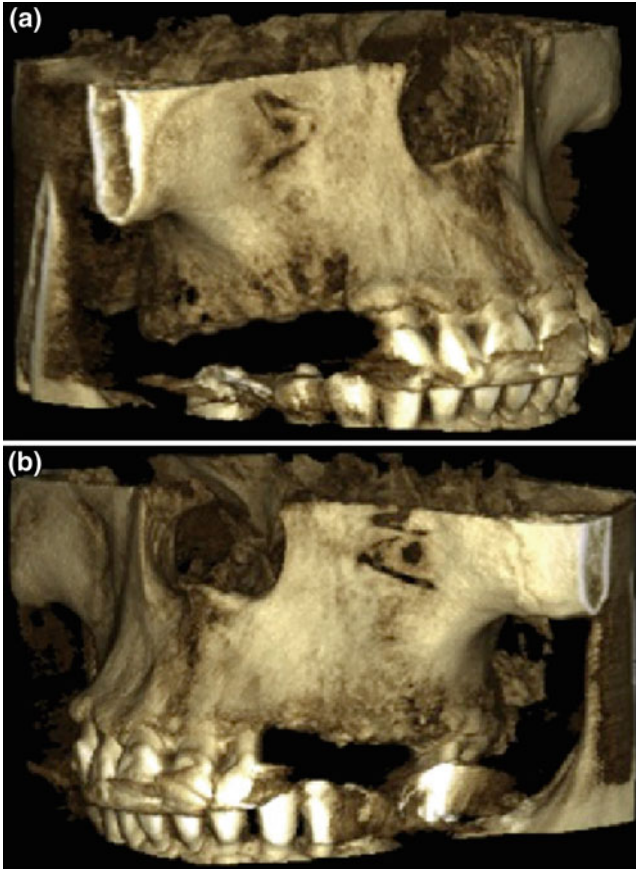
Preoperative CBCT: 3D reconstruction of right (a) and left (b) edentulous maxillary arch
